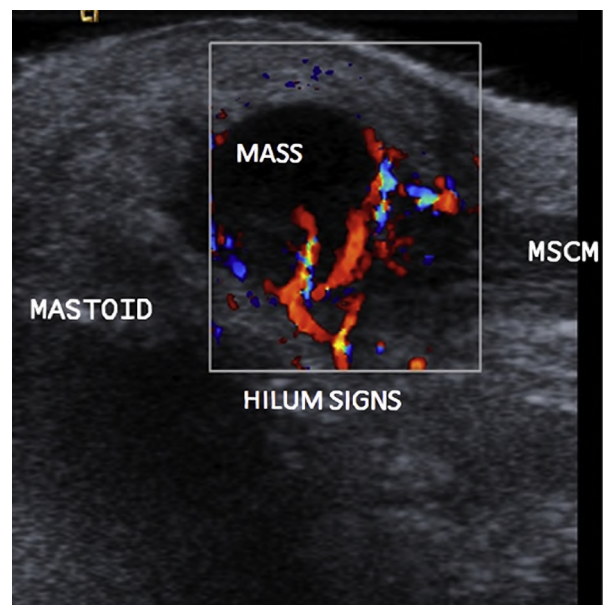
Color duplex sonography image of an inflamed retro-auricular lymph node. MSCM = sternocleidomastoid muscle.
